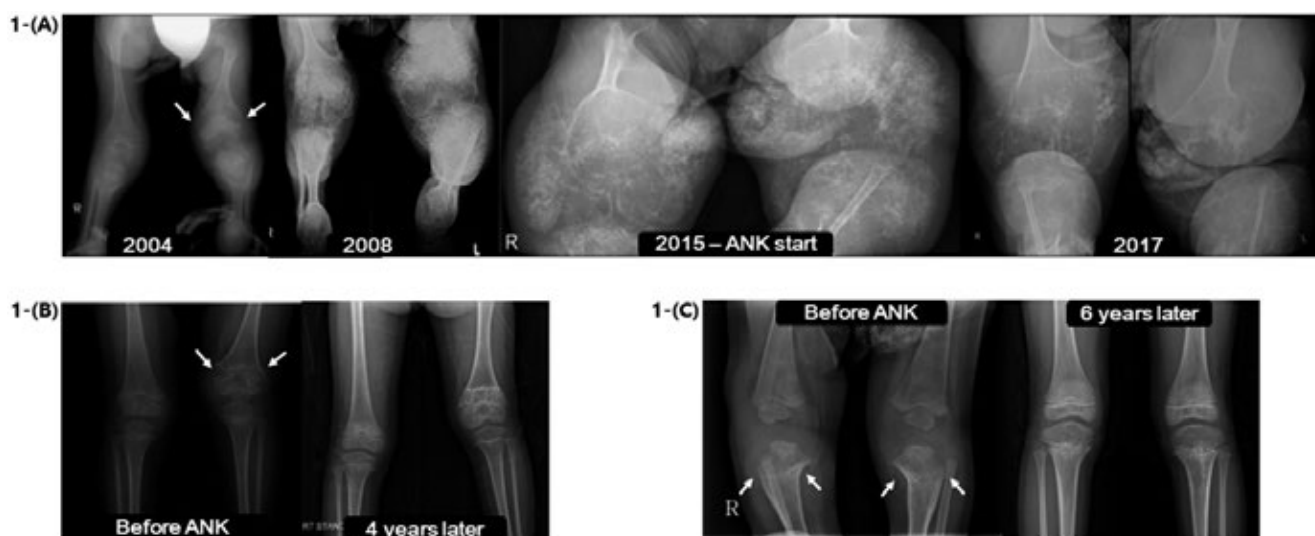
Simple radiographs of knee joint. White arrows indicate metaphyseal fraying and cupping and widening of the growth plate. 1-(a). Patient 2 with irreversible hip, knee, and ankle joint destruction. This patient started treatment with Anakinra (ANK) 14 years after diagnosis. 1-(b). Patient 10 with asymmetric distal femur involvement. This patient developed limb length discrepancy despite treatment. 1-(c). Patient 6 who restored normal joint anatomy after use of anakinra 10 months after diagnosis.
